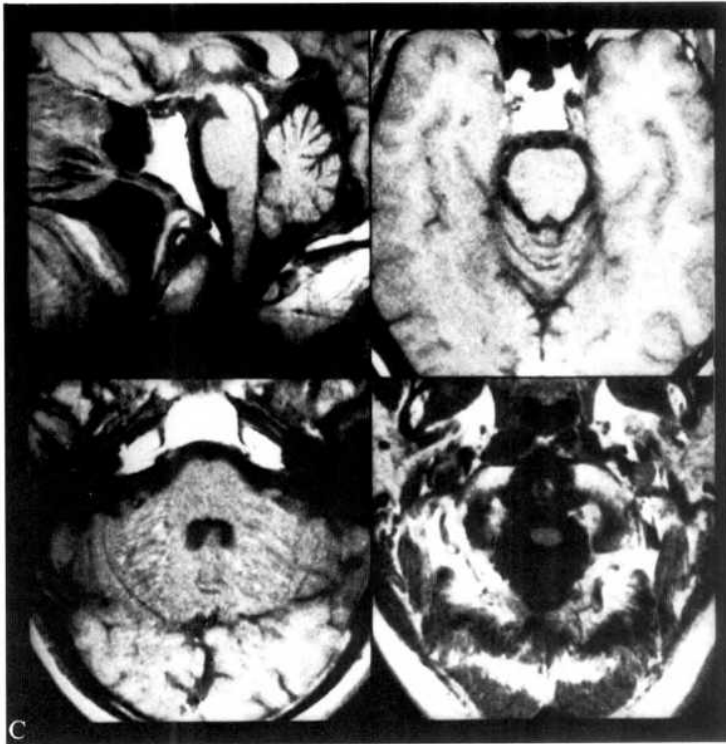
A, magnetic resonance imaging (MRI) of a 25-yr-old female patient with early onset cerebellar ataxia with retained tendon reflexes and a disease duration of 5 yrs (EOCA, Case 4). Midsagittal and axial T₁-weighted spin echo images (1.5 T, TR = 0.6 s, TE = 15 ms) demonstrate atrophy of the cerebellum affecting upper and lower vermis and hemispheres. The cervical cord is not atrophic. B, MRI of a 35-yr-old female patient with Friedreich's ataxia and a disease duration of 16 yrs (FA, Case 4). The cervical cord is markedly shrunken, whereas the cerebellum and brainstem appear intact. C, MRI of a 43-yr-old male patient with EOCA and a disease duration of 33 yrs (Case 10). Cerebellar structures appear normal, but the cervical cord is moderately atrophic.
